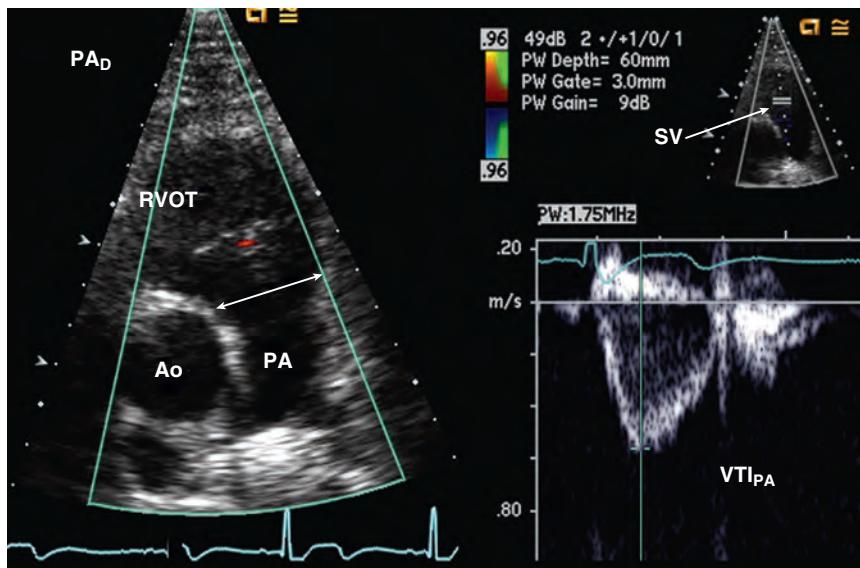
Doppler stroke volume in the pulmonary artery. Diameter is measured in a parasternal RV outflow view (RVOT; left) and pulsed Doppler pulmonary artery (PA) flow recorded from a parasternal approach (right) for transpulmonic stroke volume (SV) calculation. PA_D, pulmonary artery diameter; VTI_{PA}, pulmonary artery velocity-time integral.
